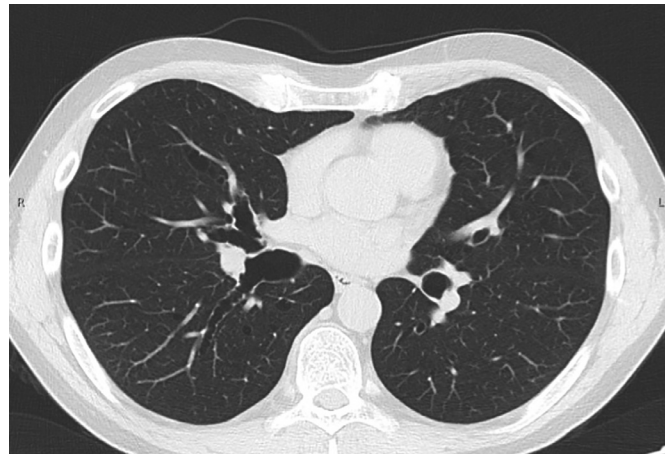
Thoracic computed tomography (CT) demonstrates dilatation of the trachea, measuring about 40 mm.
